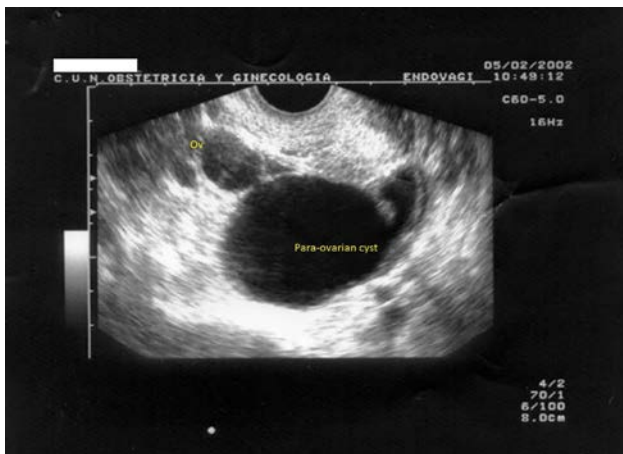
Transvaginal ultrasound depicting a para-ovarian cyst, located close to the ovary (Ov).
